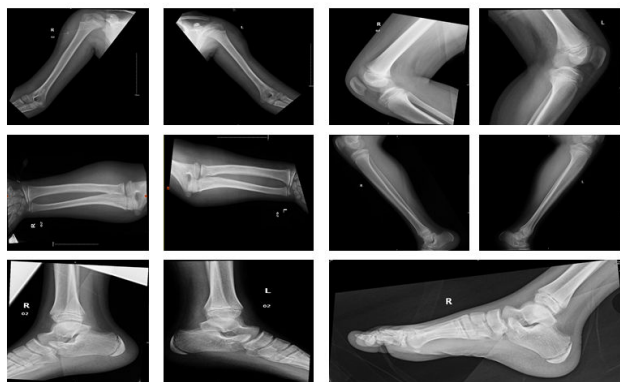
Initial X-rays of Extremities.
